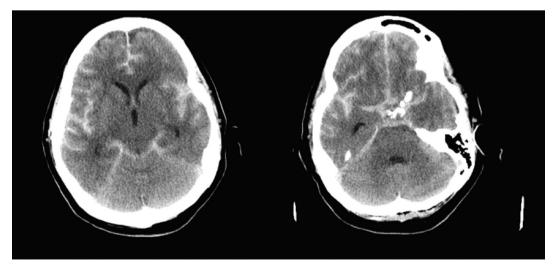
CT scan showing diffuse SAH shortly after embolization.
